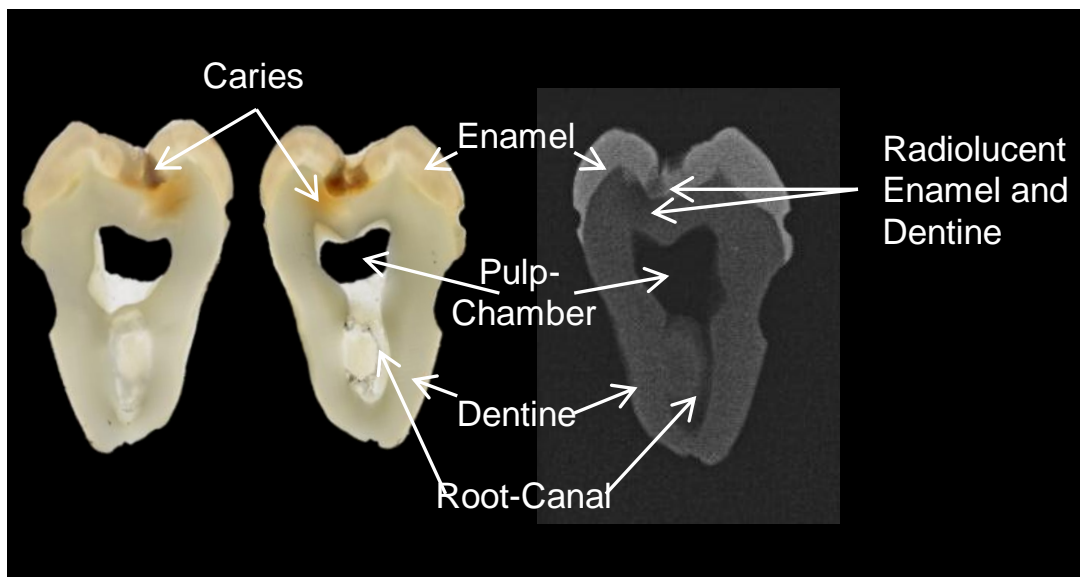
Tooth 2 tissue-slice 4, photographed both sides (front and back) and corresponding radiograph taken at 60kV 7mA 0.125s showing enamel, pulp-chamber, dentine, root-canal and demineralised carious tooth-tissue in both enamel and crown-dentine which is radiographically more radiolucent than the respective normal tissue.
